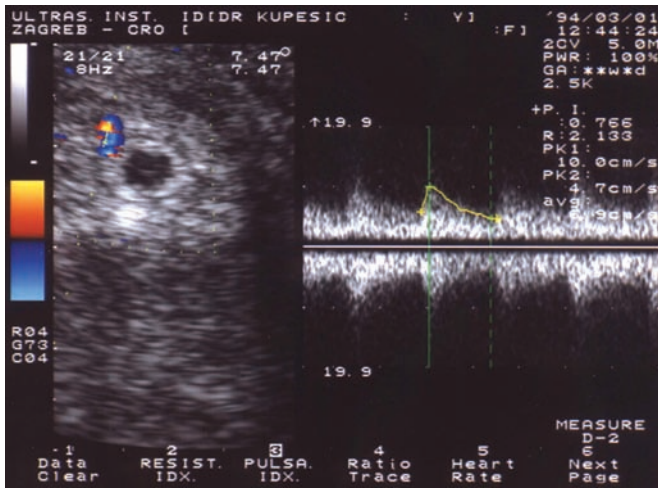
Transvaginal power Doppler imaging of a gestational sac at 5/6 weeks' gestation. This technique easily depicts blood flow surrounding the gestational sac.
